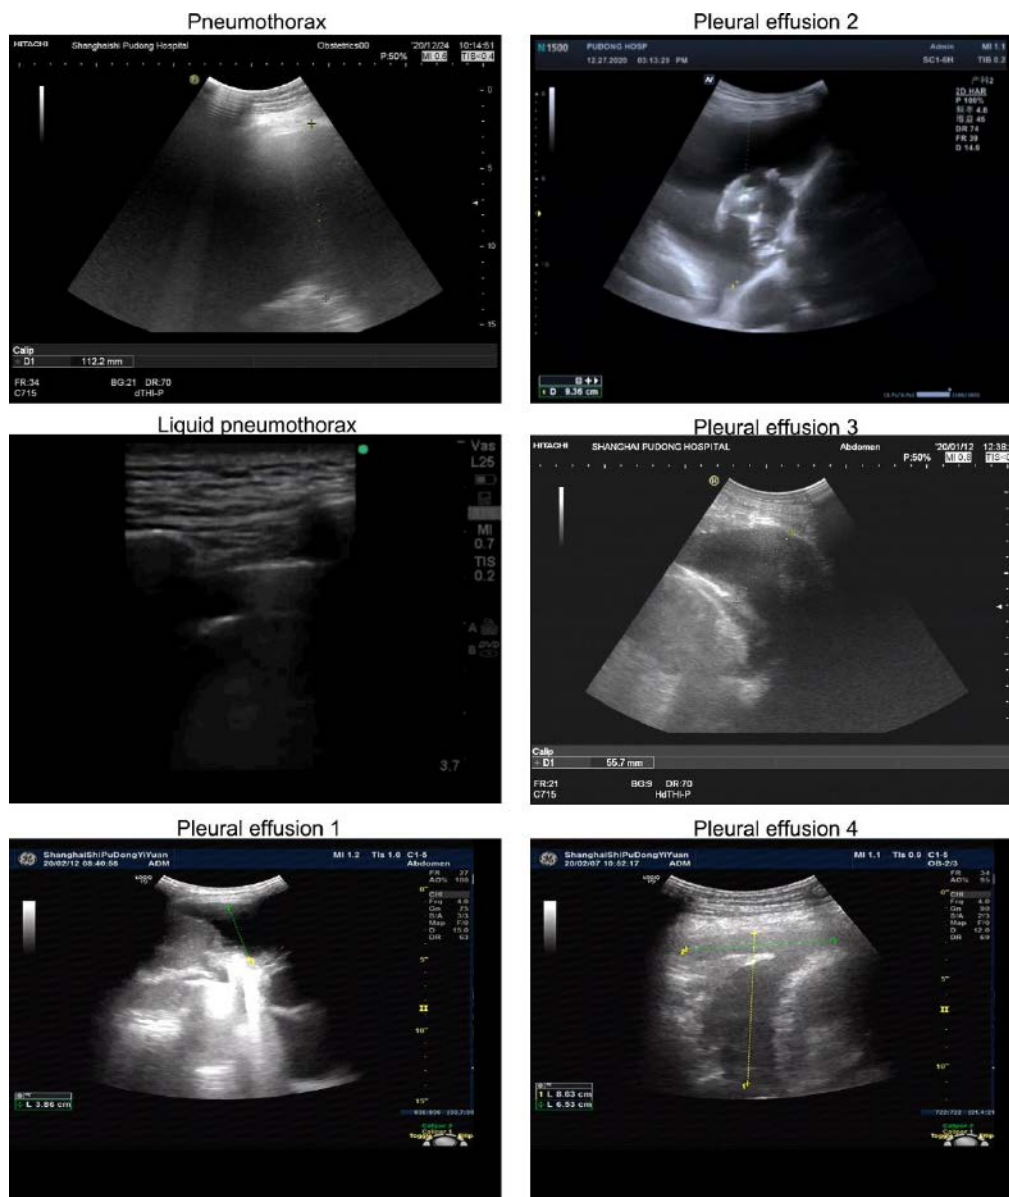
Bedside ultrasound
